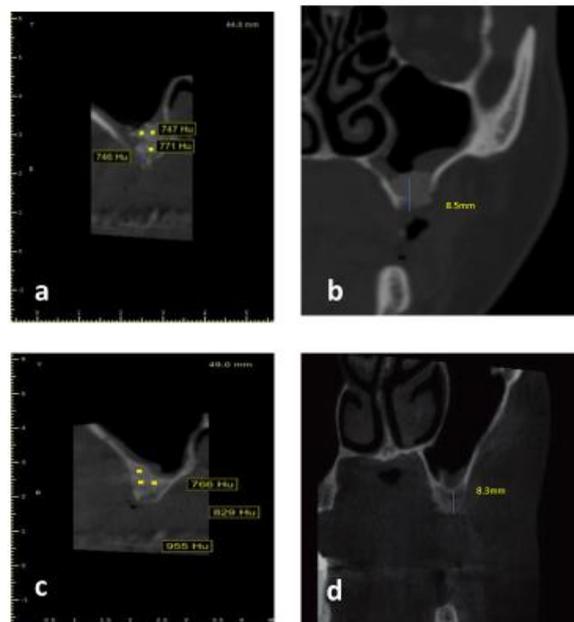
CBCT showing measurement of (a) Immediately postoperative bone density. (b) Immediately postoperative bone height (c) postoperative bone density after 9 month (d) postoperative bone height after 9 months
